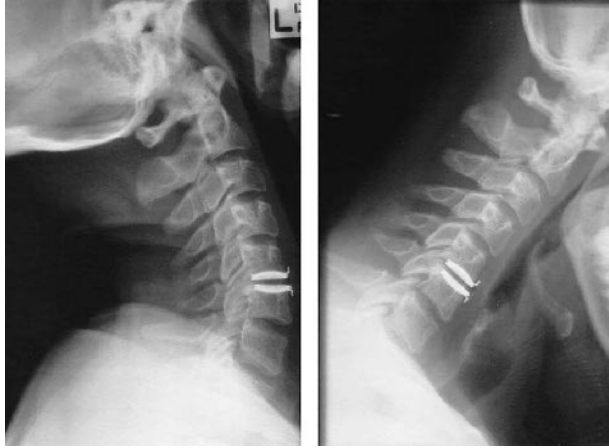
Lateral flexion/extension x-rays after placement of a C5–C6 artificial disc prosthesis from case 2. Note that normal movement occurs at the instrumented level, as demonstrated by the crowding, then splaying of the C5 and C6 spinous process.
